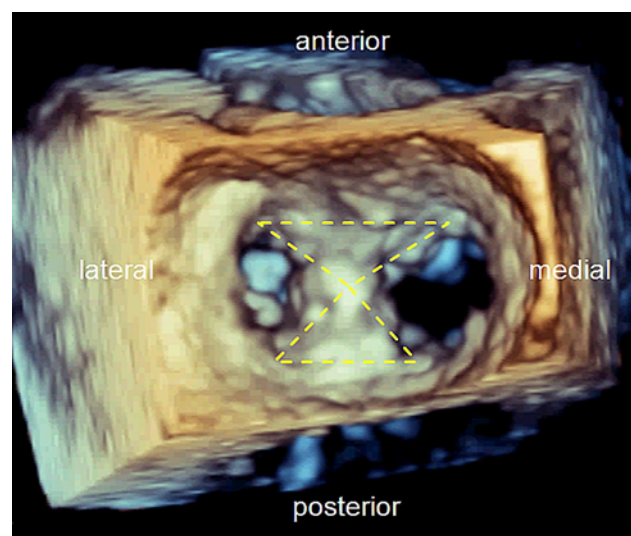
Left atrial echocardiographic 3D view of the newly created tissue bridge and both mitral valve openings
